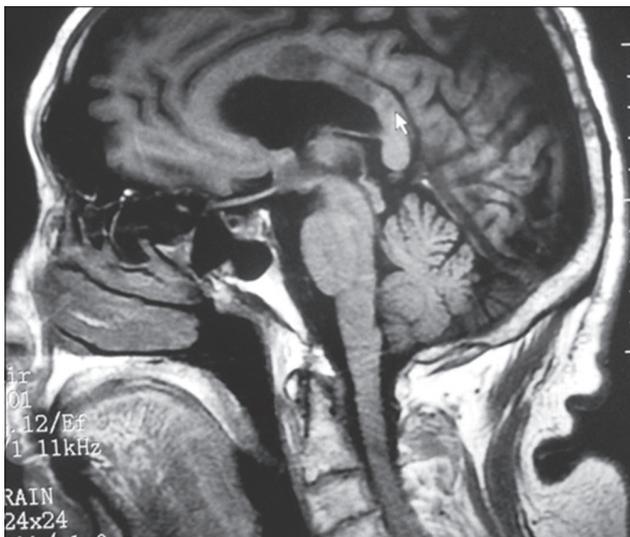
MRI showing acute infarction in the corpus callosum
